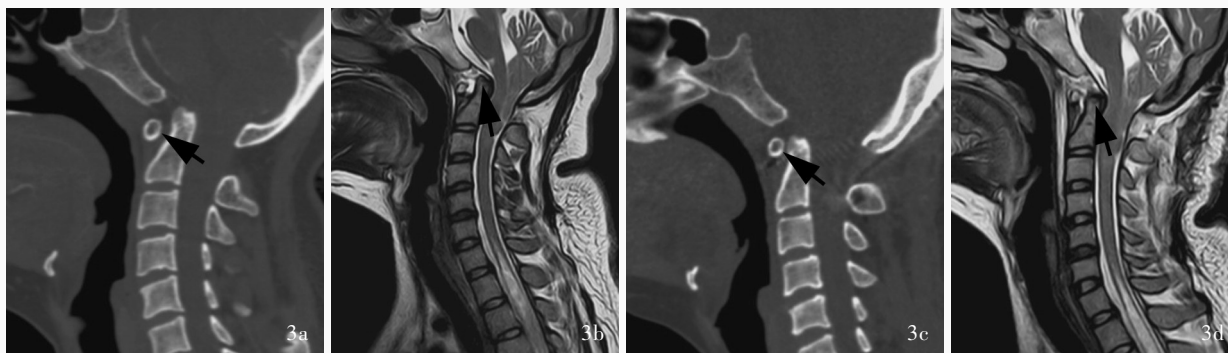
女性患者, 28 岁, 临床诊断为 Goel A 型颅底凹陷症, 于滑轨式牵引头架牵引下行后路寰枢关节间撑开复位融合术。手术前后影像学检查所见 3a, 3b 术前矢状位三维重建 CT 和 T₂WI 显示寰齿间距增宽, 提示寰枢关节脱位, 相邻椎管狭窄伴同一层面颈髓受压(箭头所示) 3c, 3d 术后 7 d 矢状位三维重建 CT 和 T₂WI 显示寰齿间距减小, 寰枢关节脱位及颈髓受压明显改善, 斜坡枢椎角及延髓脊髓角较术前增大(箭头所示)
